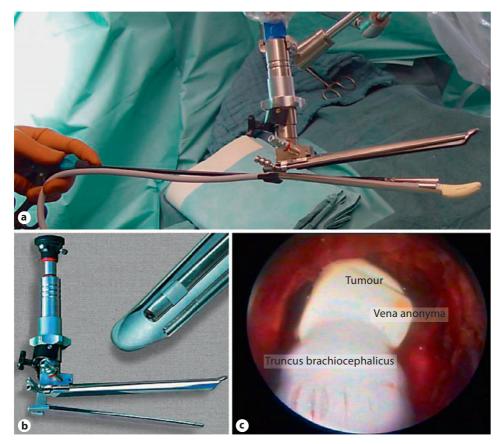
Unlike other unvariable tubular (video)mediastinoscopes, the Linder-Dahan scope (a, b) is equipped with a spreadable shaft, providing a wide operation field, being the prerequisite of bimanual dissection and development of videomediastinoscopic surgery (VAMS). Besides VAMLA, the Linder-Dahan scope facilitated techniques like mediastinoscopic ultrasound (MUS, b, c), mediastinoscopic excision of mediastinal cysts, and secondary main bronchus stump closure.
